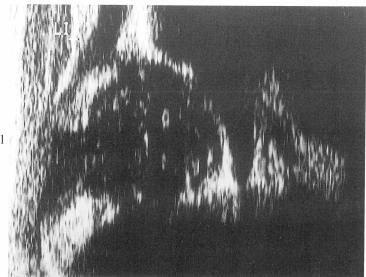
Ultrasonography of a normal hip. Graf type Ia. Figure 2. — Ultrasonography of low hip dislocation. Graf type IV.
